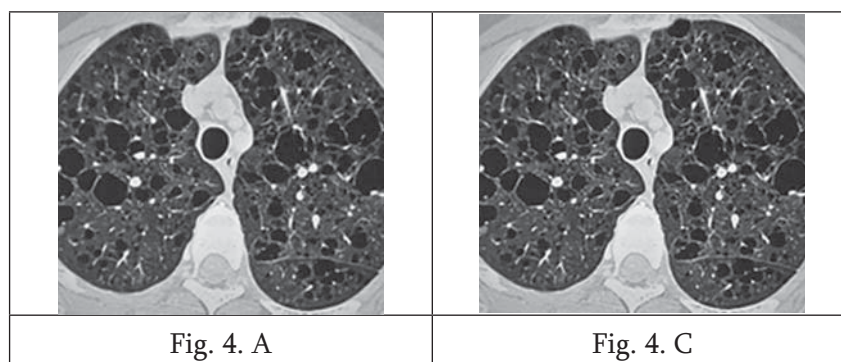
A. Lymphangiomyomatosis (LAM) CT shows numerous cysts in both lungs. Cysts are round or ovoid and relatively uniform in size and shape. Cysts are diffusely distributed without zone predominance in both lungs. B. Birt-Hogg-Dubé syndrome (BHD) Multiple lower zone predominant thin-walled cysts of varying size, many of which are about the pleura, particularly the paramediastinal pleura.
